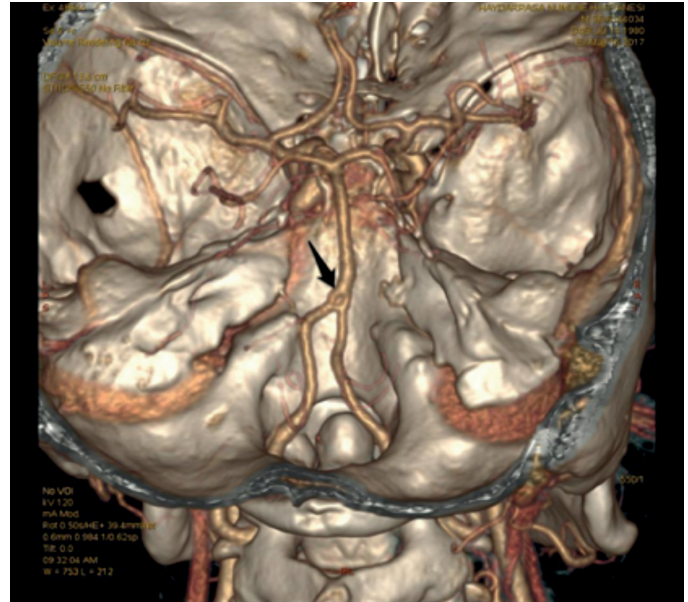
Computed tomography angiography showed a basilar artery fenestration at the distal third without any aneurysm.
